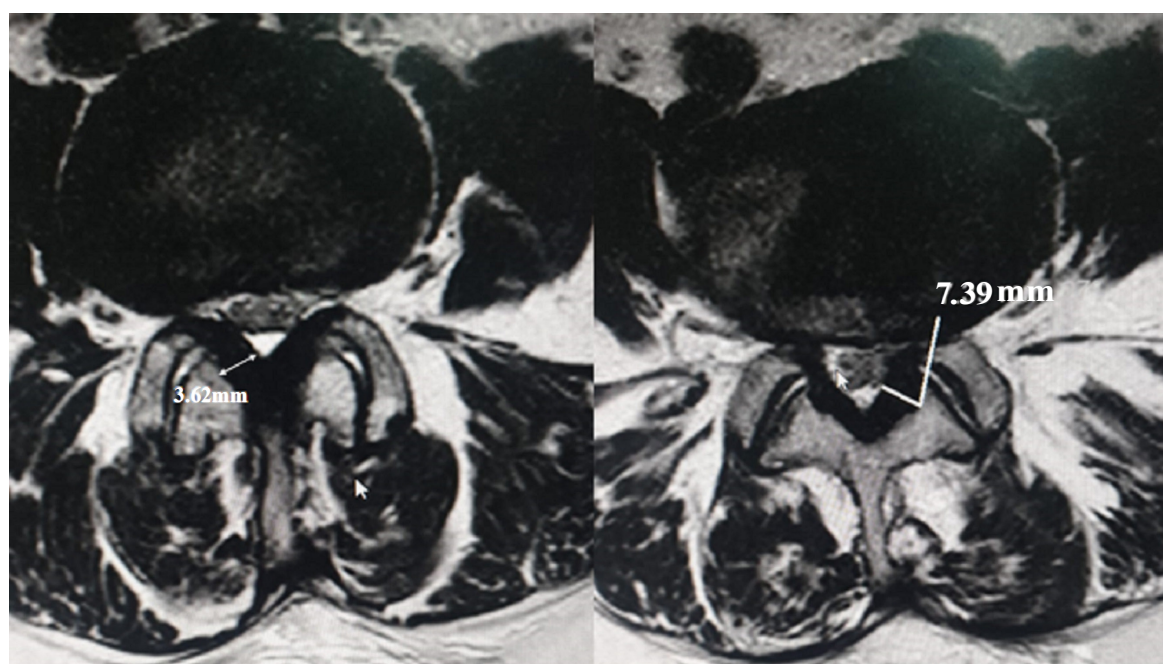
Metric analysis in T2-weighted MR sequence of a ligamentum flavum at L4-L5 level in the axial plane.
